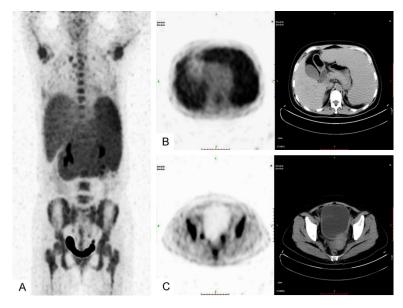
PET-CT of the whole body. A: Systemic bone diffuse lesions; B: Splenomegaly; C: Pelvic cystic mass.
